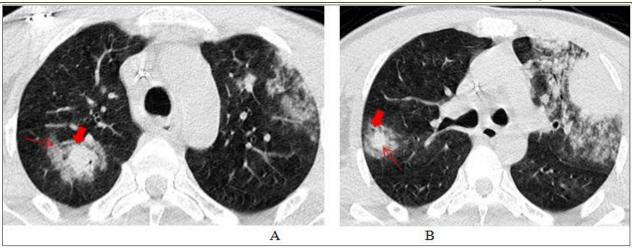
A and B, Eariy CT findings of invasive pulmonary aspergillosis in a patient with leukemia and aplasia. The CT halo sign represents a discrete zone of lower attenuation (small arrows) surrounding a pulmonary mass (large arrows).
